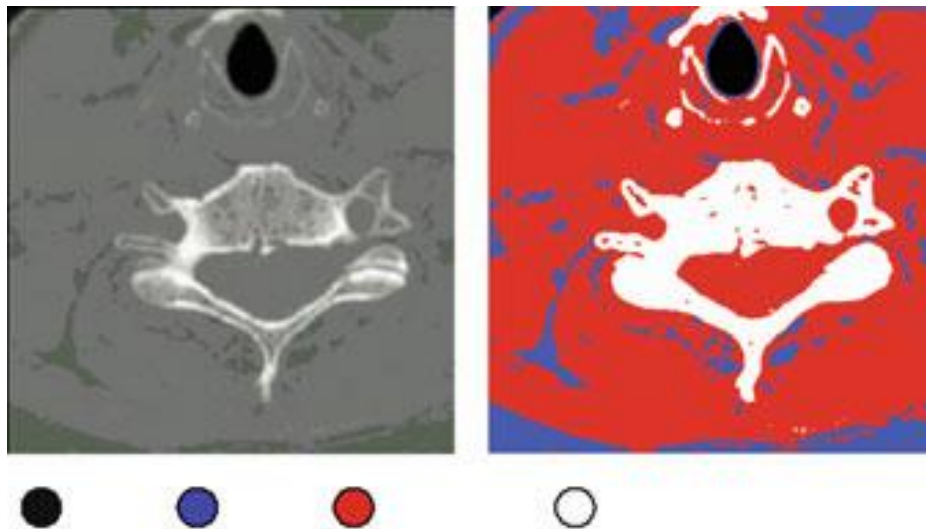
Segmentation of different tissues in a CT image. In different colors are discriminated the different types of tissues (black for background, Blue for fat tissue, Red for water and white for bone structures). (Adapted from [4])
